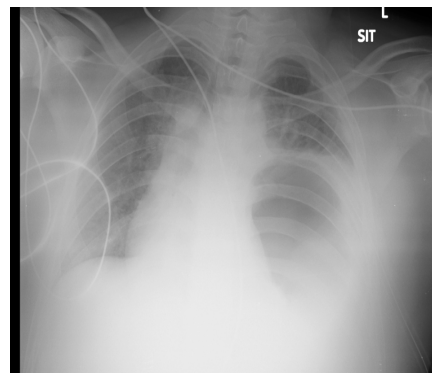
Chest X-ray showing stomach herniation to the left hemithorax.
